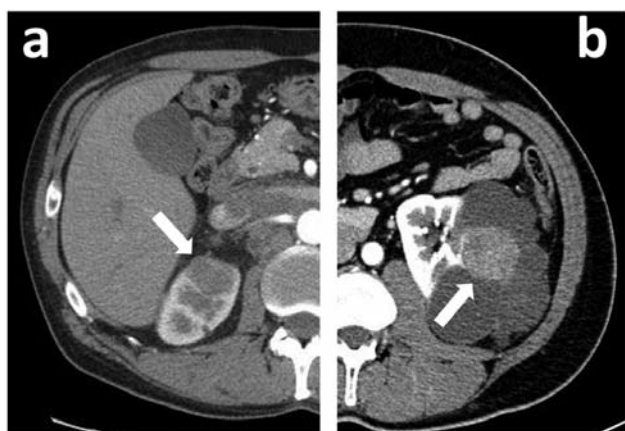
Radiographic aspect of primary collecting duct carcinoma (arrow) arising centrally (a) or among cystic lesions of the kidney (b). Both images are characterized by a minimally-contrast capture reflecting the low vascularization of the tumor.
